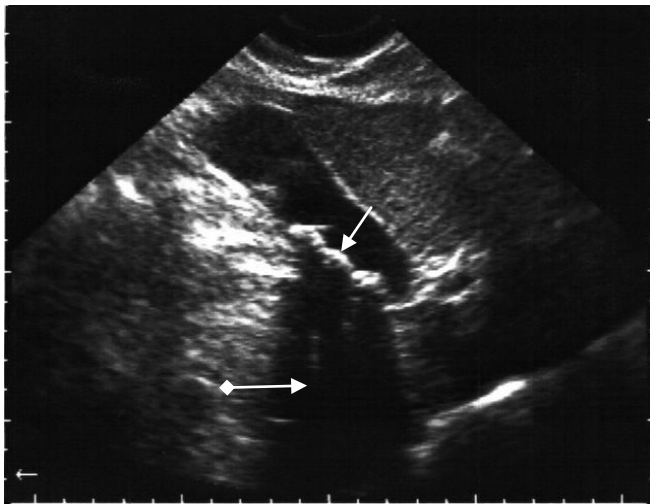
Ultrasound of gallbladder. Stones on sonogram look like highly reflective echogenic focus within gallbladder lumen (arrow) with prominent posterior acoustic shadow (arrow with rhombus). Cholelithiasis
